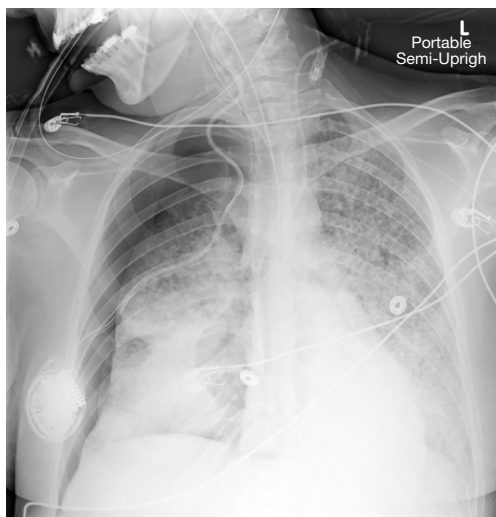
Large right sided pneumothorax on frontal portal chest X-ray in a patient on mechanical ventilation occurring after the patient had a chest wall biopsy.
